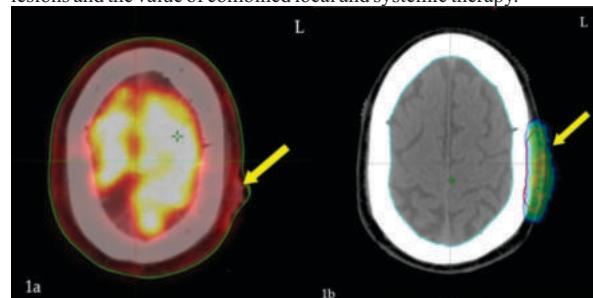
PET/CT axial image demonstrates intensely hypermetabolic scalp lesion with well-defined margins (yellow arrow), overlying the left parietal region.
